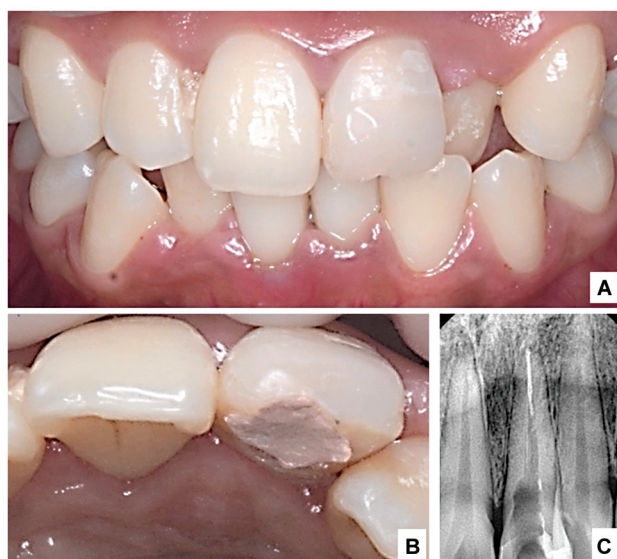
(A) Labial appearance, (B) occlusal appearance of tooth no 21, and (C) radiographic finding of tooth no 21.
